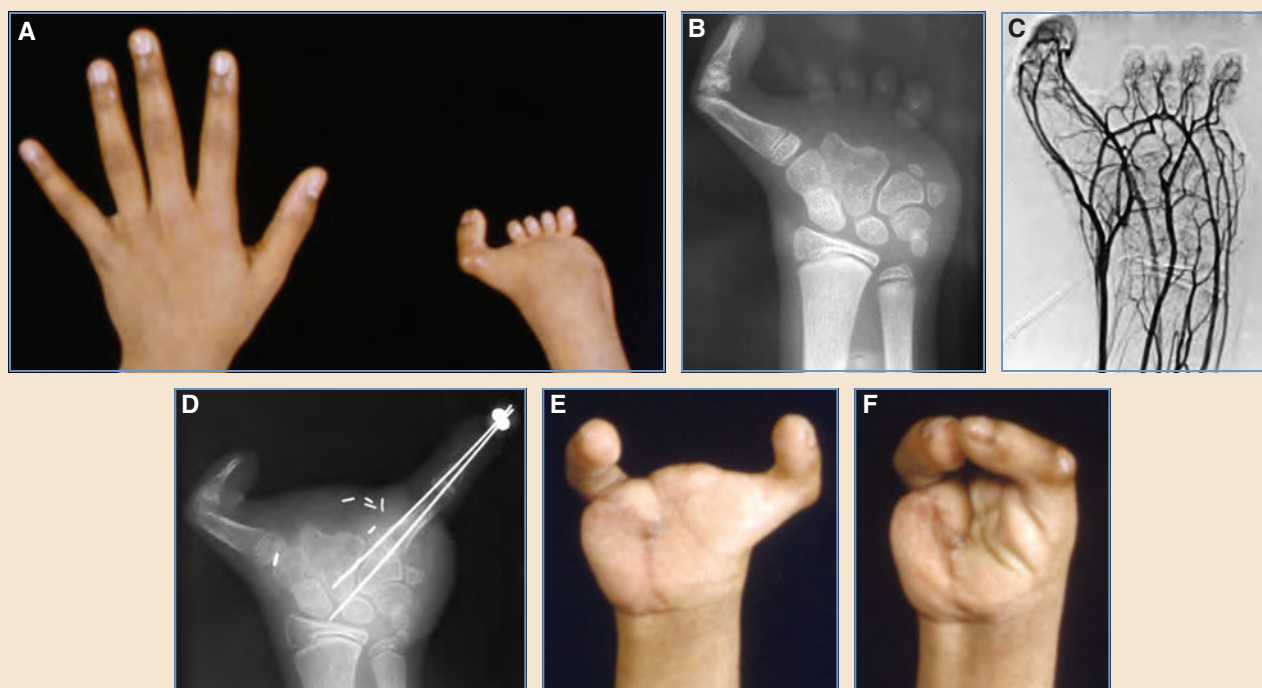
A, This 12-year-old's right hand had symbrachydactyly with a poor thumb and only nubbins representing the rest of the fingers. The patient was only able to hold very small objects in this hand. A two-stage reconstruction was performed. The first stage involved the thumb, and the second involved the ulnar digit. B, The lax thumb was reconstructed using an intercalary bone graft of fibular hemicortex, shown in a radiograph, to stabilize the thumb. A passive prosthesis was fitted on the ulnar side of the hand with a methylmethacrylate model of the proposed toe transfer. This prosthesis provided an opportunity to test various potential positions for the new digit. C, An AP arteriogram of the hand revealed an intact deep volar arch and a persistent median artery. A large ulnar artery was seen and was the planned vessel for arterial reconstruction. D, The second toe was transferred to the ulnar hand and held in place with two K-wires. The cartilage was shaved from the opposed surfaces at the osteosynthesis site. E, A postoperative volar view shows a second toe-to-ulnar hand transfer in place. The maximum extension is shown. It allows gross grasp sufficient for moderately sized objects. F, Pulp-to-pulp pinch is achieved mostly with thumb and metacarpal movement, with little movement in the transferred toe.
